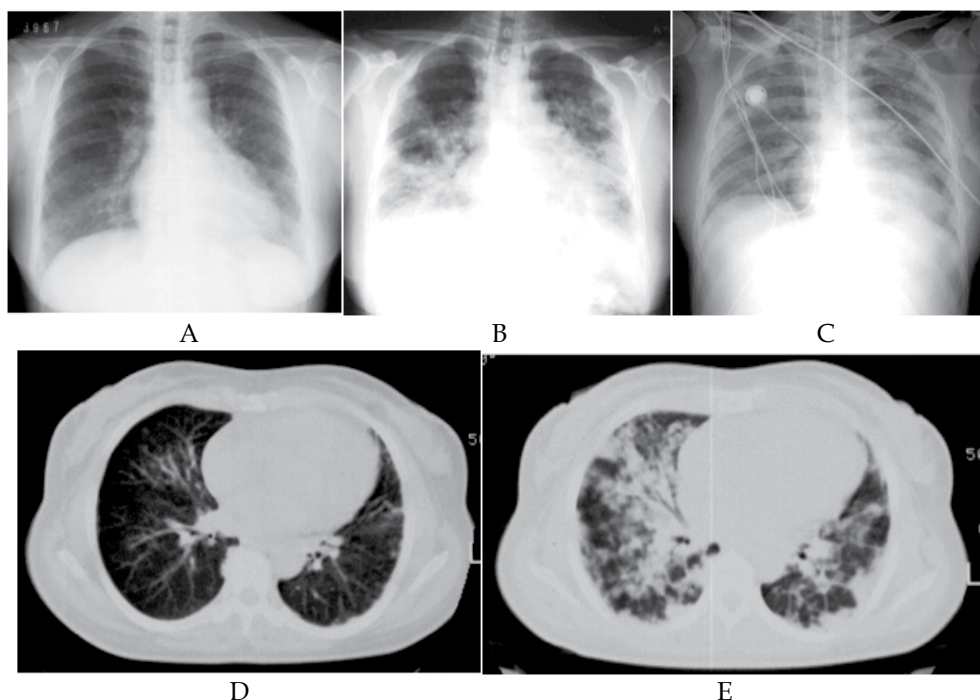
Chest radiographs and computed tomography of a case with rapidly progressive interstitial lung disease associated with clinically amyopathic dermatomyositis. Very slight interstitial lung disease (A, D) deteriorated to be fatal in three months despite high dose corticosteroid treatment (B, C, E).
